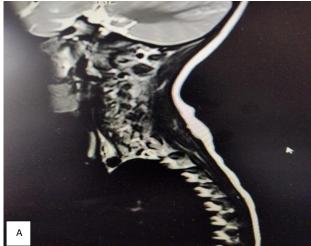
(A-C): MRI spine dated 07/11/2022 patchy ill-defined mild hyperintense non enhancing lesions are seen in spinal cord at C5- D2 and D7-D10 vertebral levels. Above features s/o myelitis.
